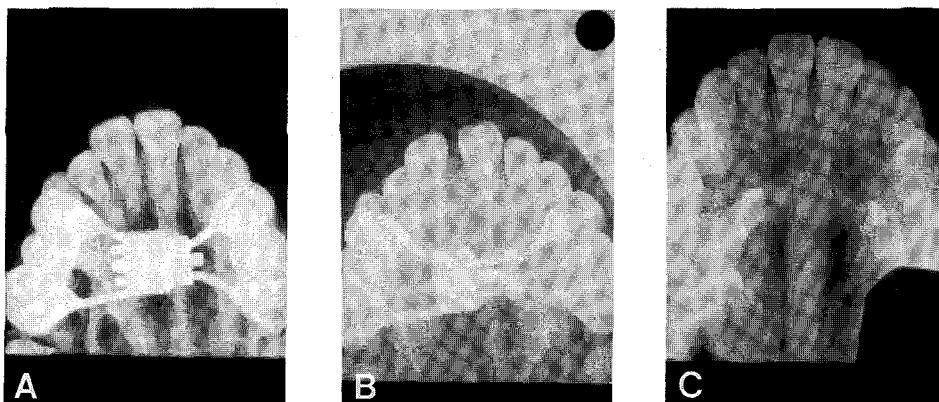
Serial occlusal x-rays before and after expansion, and at the follow-up retention after 18 months
